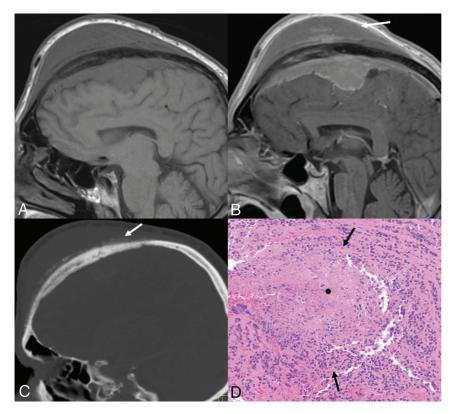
Transcalvarial frontal atypical, grade 2 meningioma in a 54-year-old man. Sagittal TI-weighted (*A*) and contrast-enhanced (*β*) images reveal a large frontal convexity meningioma with intraosseous components and transcalvarial extension into the scalp (*β*, *arrow*). Mild hyperostosis of the adjacent calvaria along with a "hair-on-end" periosteal reaction along the outer table is seen on CT (*C*, *arrow*). Tumor shows meningothelial morphology, with, however, other features such as focal spontaneous necrosis (*D*, *asterisk*) and peripheral nests of tumor cells (*D*, *arrows*). A high Ki-67 rate in hot spot areas and areas of tumor that are devoid of progesterone receptors is also noted, supportive of the diagnosis of atypical meningioma (WHO grade 2). Mitotic count of 4 mitoses per 10 high-power fields is noted, on its own fulfilling the criteria for a diagnosis of an atypical meningioma.
